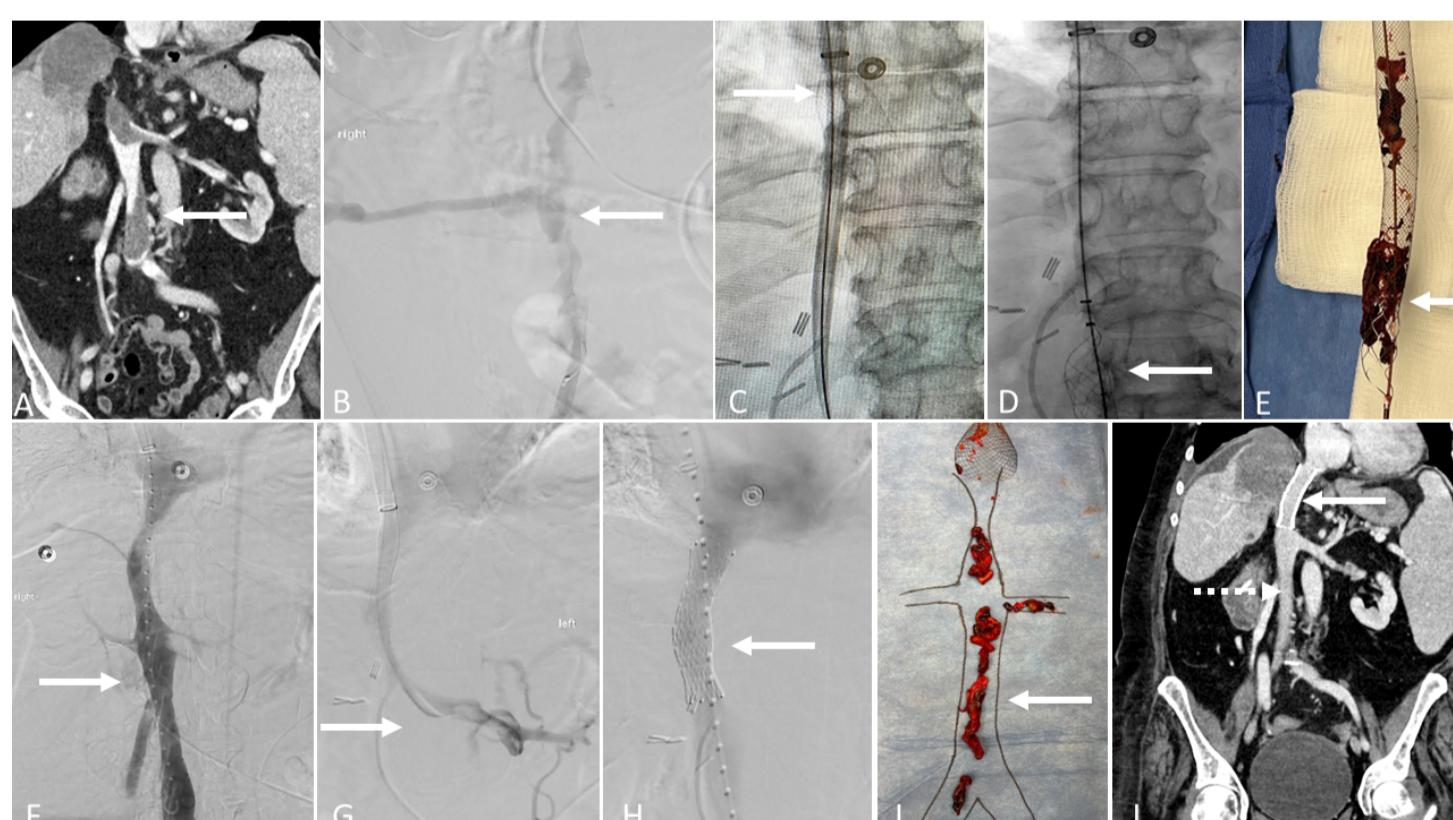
Preprocedure CT venography demonstrates thrombus within the intrahepatic IVC, left renal vein, infrarenal IVC, and right common iliac vein (A). Venography of the IVC indicates significant clot burden in the IVC with poor flow (B). A 20F Protrieve sheath was placed in the IVC (C), and the funnel was subsequently deployed below the cavoatrial junction. Mechanical thrombectomy was performed with the ClotTriever BOLD catheter from the popliteal vein up to the IVC (D). Extracted thrombus is seen within the coring element and collection bag following 1 of 4 passes with the ClotTriever device (E). Repeat venography confirmed that no residual thrombus remained in the IVC (F). Venography of the left renal vein was performed (G). A Venovo stent was deployed in the intrahepatic IVC (H). Extracted thrombus (I). One-month post-procedure CT venography demonstrating patency of IVC stent (J; solid arrow), remainder of the IVC, and left renal vein (J; dashed arrow).
